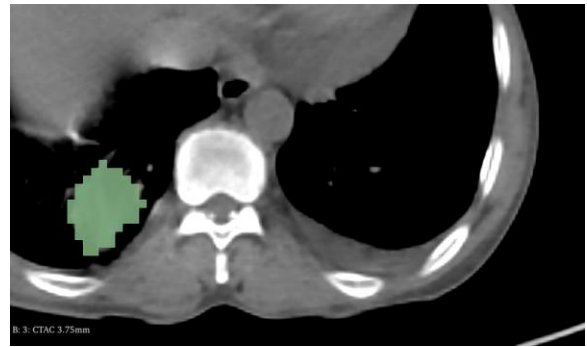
Image of a lung tumor marked on a slice from a CT scan.
